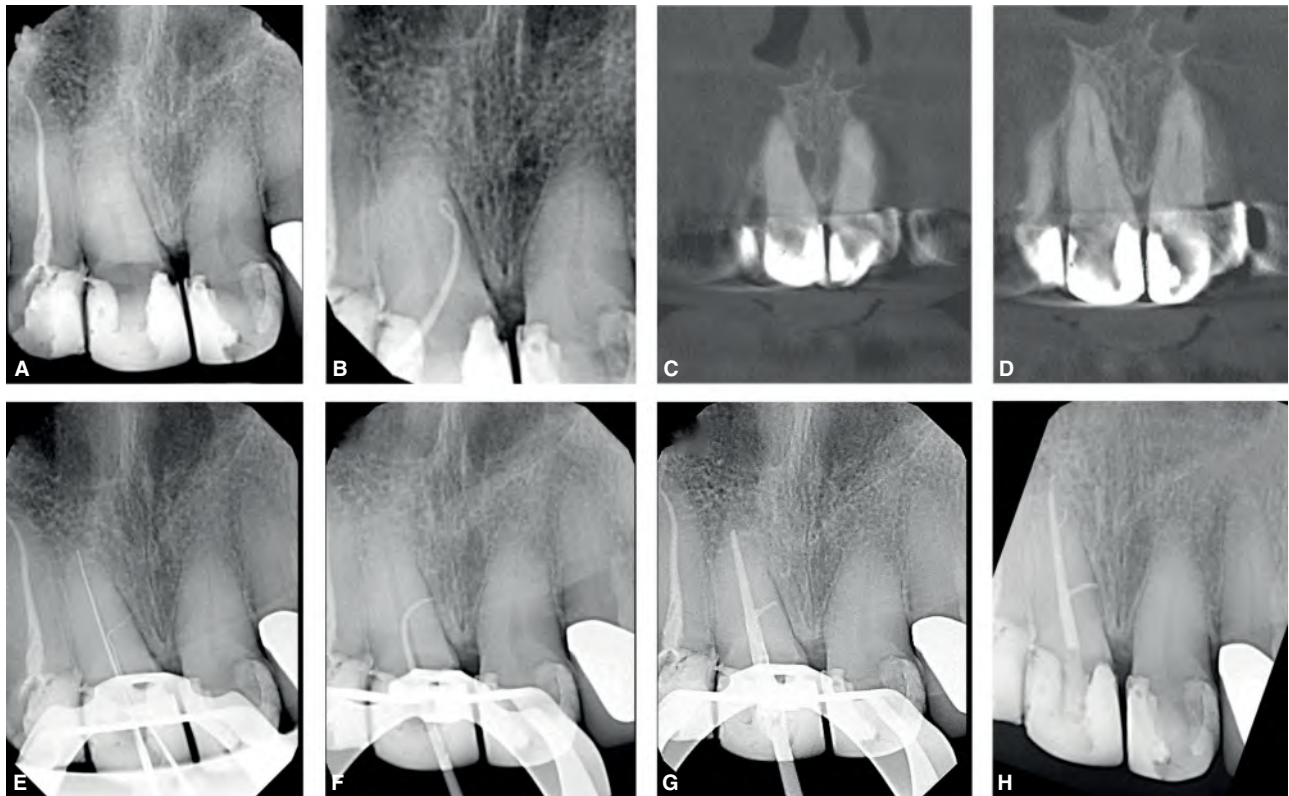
A,B*, Preoperative radiograph showing the maxillary right central incisor with healthy periapical tissue and a midroot sinus tract that traces to the mesial surface of the root. *C,D*, Coronal view CBCT images reveal a lateral lesion and an associated lateral canal. *E-H*, Based on CBCT measurements, the lateral canal was negotiated with hand files, then enlarged up to size 30/04, using rotary files, and filled using warm vertical condensation of gutta-percha. (Courtesy of Dr. Adham A. Azim, Buffalo, NY.)
